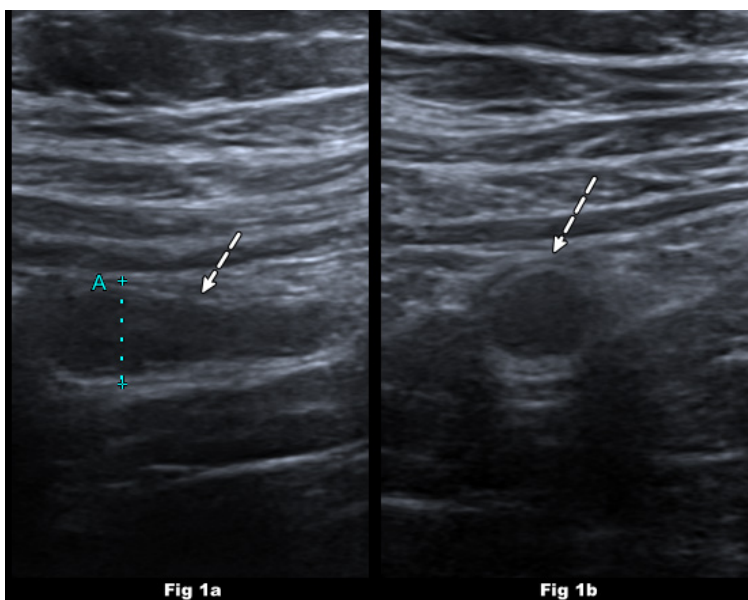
a,b. The ultrasound images of a 12-year-old boy with complaints of nausea and right lower quadrant pain show an aperistaltic appendix with an increased diameter (10 mm) (arrows) and inflammation in the surrounding fatty tissue. US findings are compatible with acute appendicitis.
